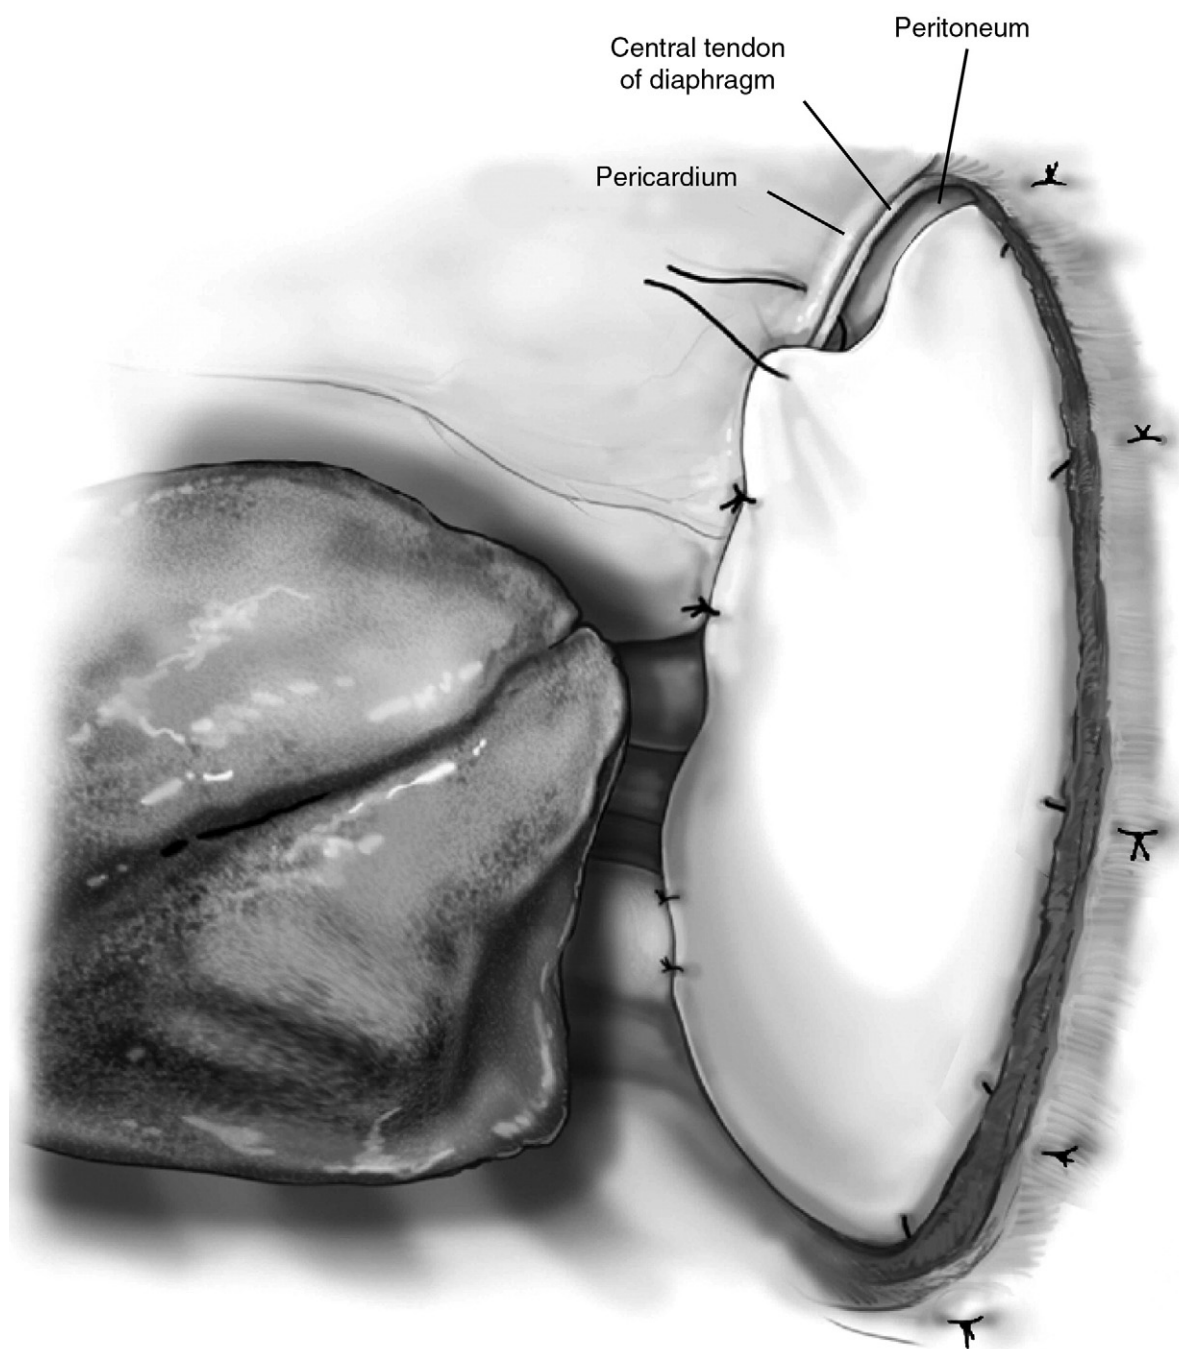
Repair of the diaphragm: After resection of the diaphragm, care must be taken to repair the diaphragm by attaching the diaphragmatic patch to the pericardium. In addition, the patch must be pulled taut to protect the residual lung from loss of domain and atelectasis caused by upward motion of the abdominal organs. On the right, a double-layer Dexon mesh (Covidien, Norwalk, CT) is adequate. On the left, 2-mm-thickness Gore-Tex (W.L. Gore & Associates, Inc, Flagstaff, AZ) is used because a thicker, nonabsorbable material is needed to prevent herniation of abdominal contents. The prosthesis is secured laterally by sutures placed around the ribs through the soft tissue of the chest wall. (Reprinted with permission from Wolf AS, Daniel J, Sugarbaker DJ: Surgical techniques for multimodality treatment of malignant pleural mesothelioma: extrapleural pneumonectomy and pleurectomy/decortication. *Semin Thorac Cardiovasc Surg* 21:132-148, 2009.)
